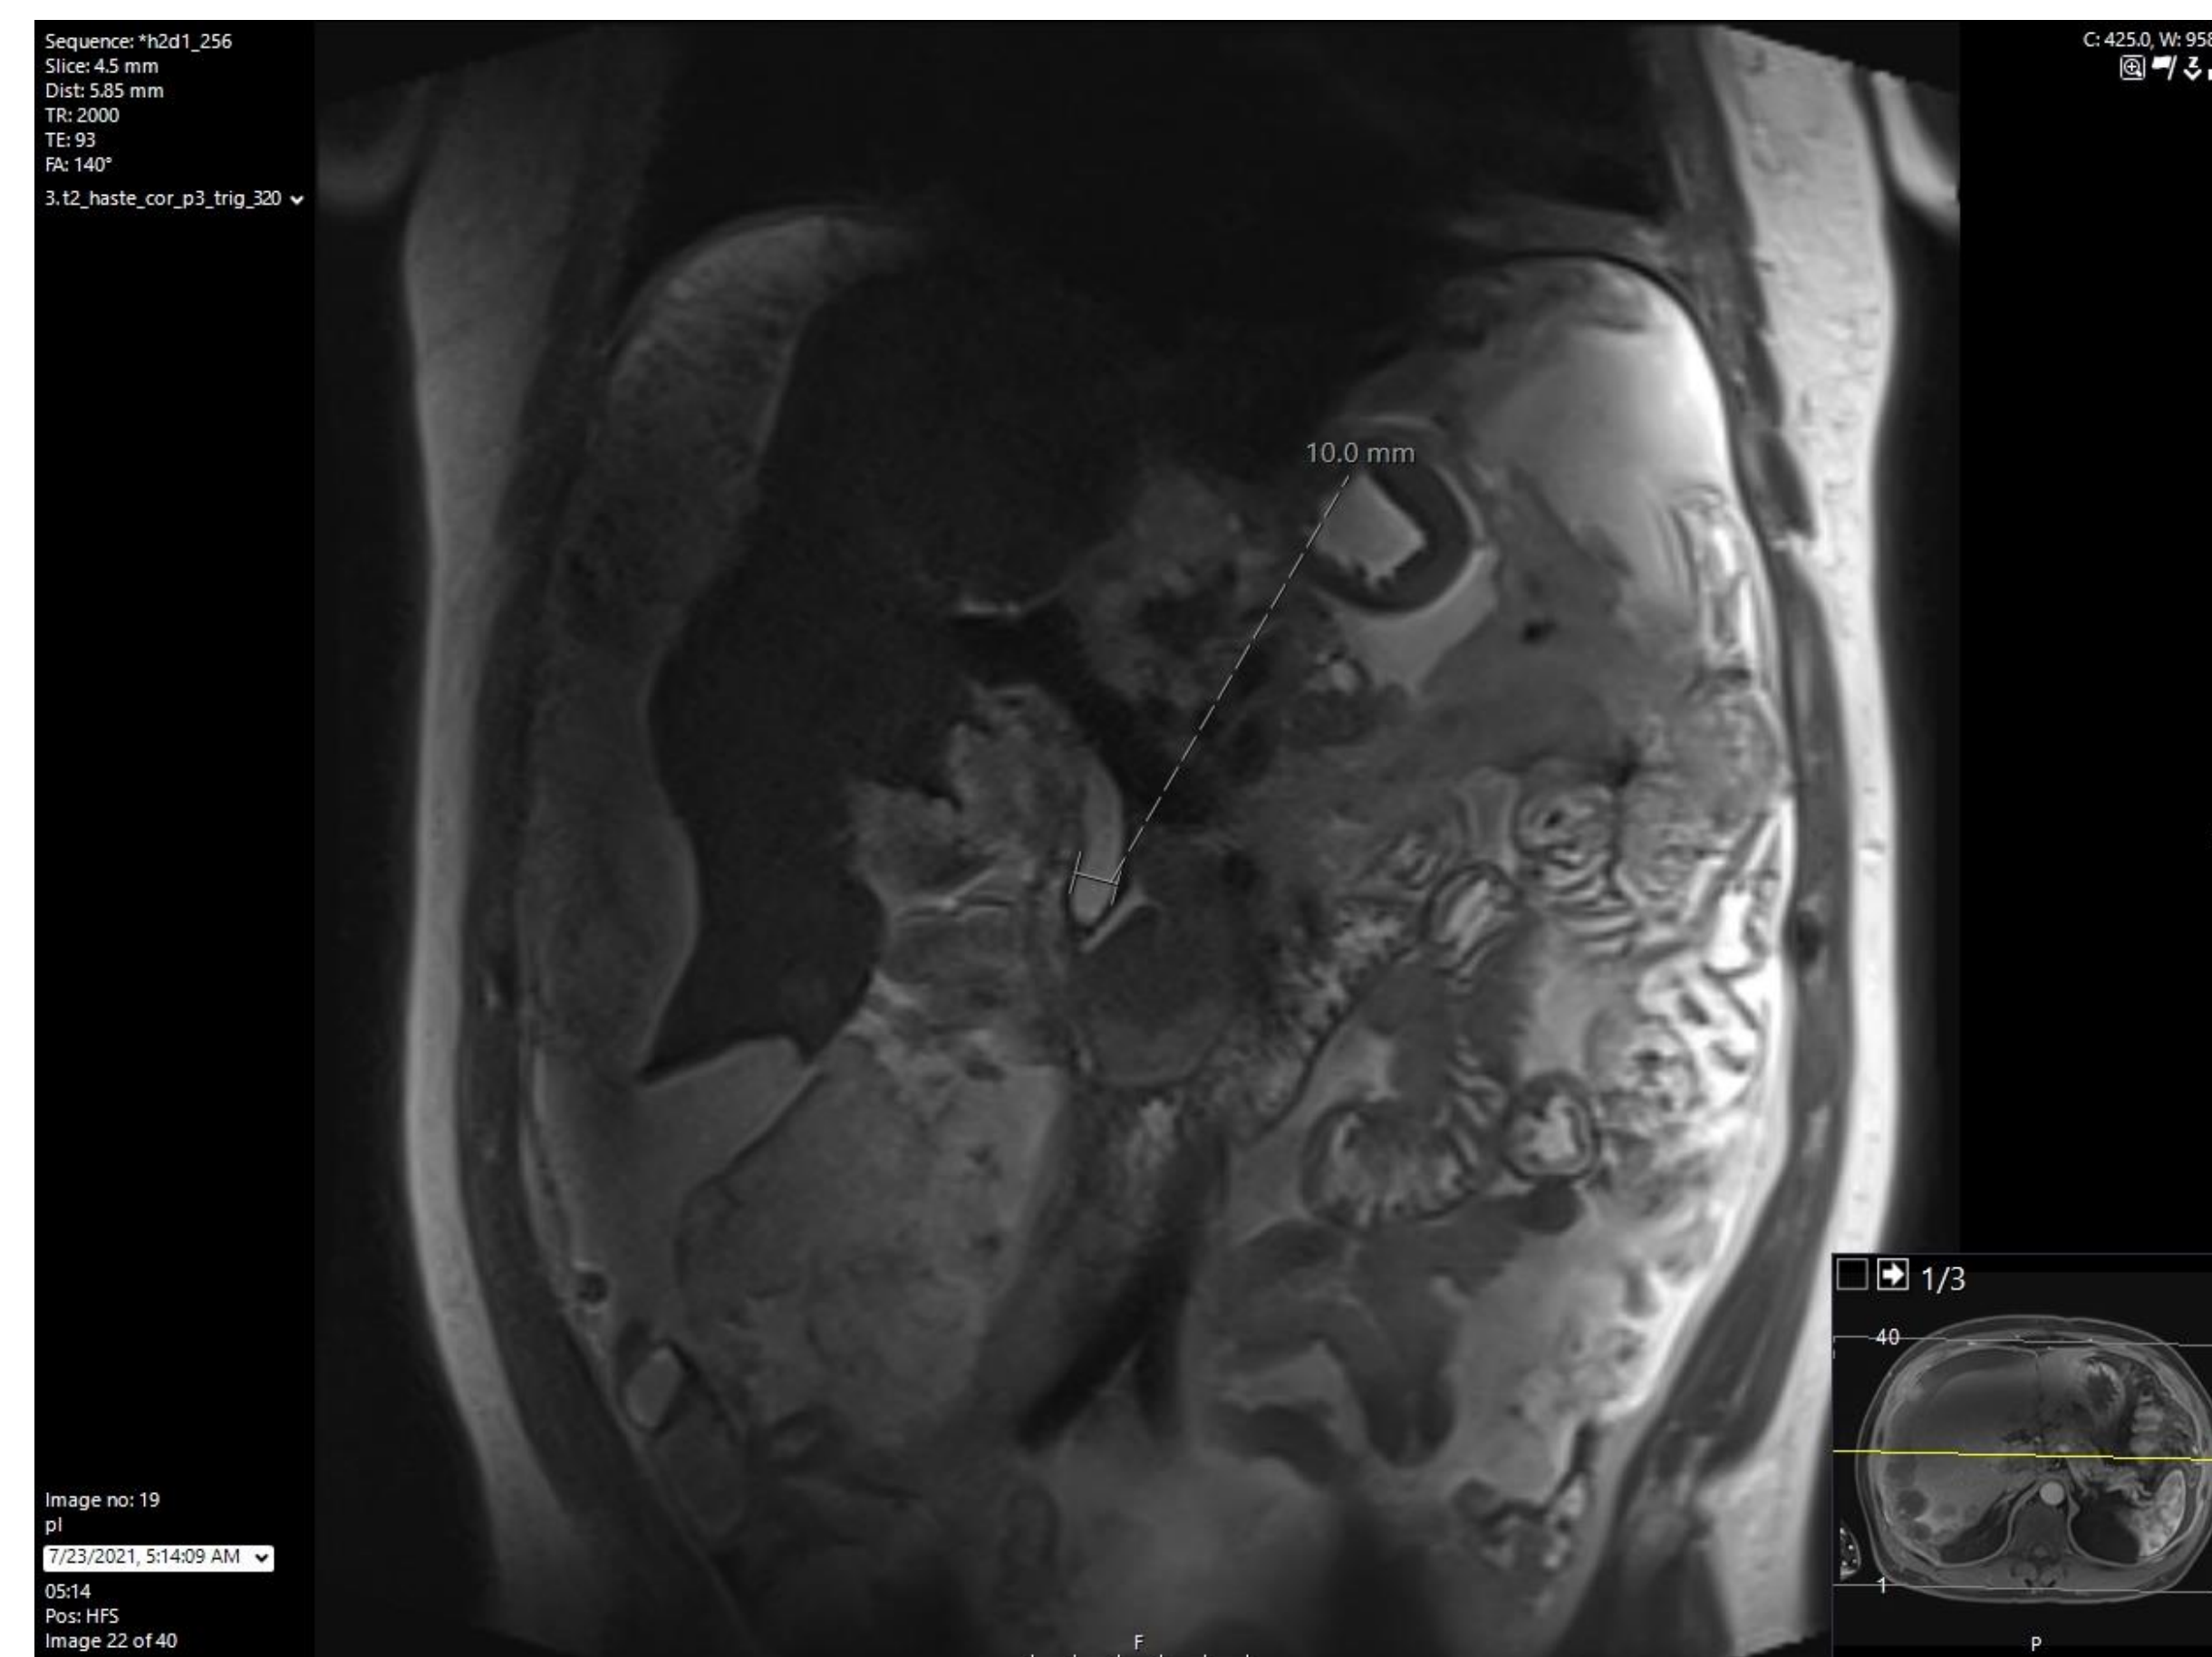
MRI showing dilated Common Bile Duct and Pancreatic duct
